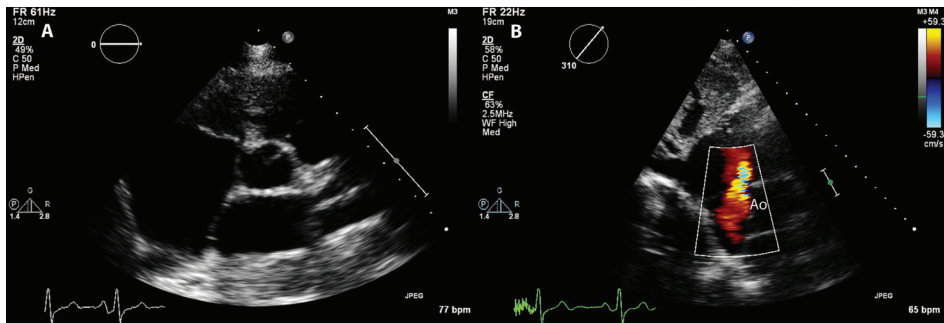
Standard parasternal SAX view at the aortic valve level: showing the misinterpreted intact aortic rim (left) whereas with a 310° rotation the true absent aortic rim can be appreciated (right).
